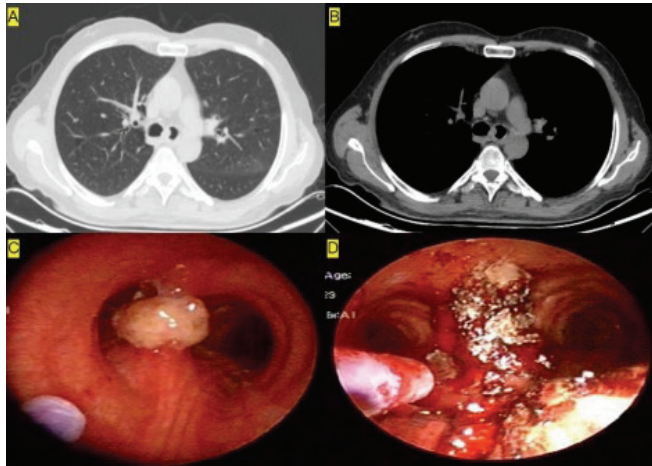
CT bronchoscopy and images of the lesion localized in the carina. A: Parenchymal section CT image of the lesion in the carina localization, B: Mediastinal section, C: FOB image of the lesion, D: Open image of the left main bronchus after the carina.
